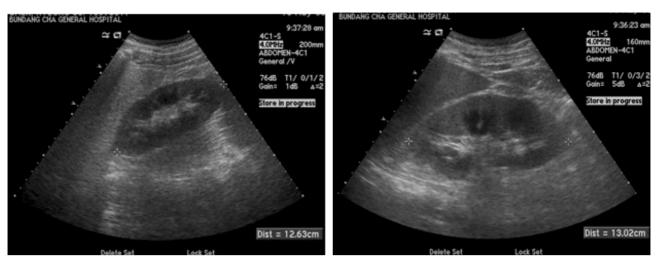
Abdominal ultrasonographic findings. Both kidneys were enlarged (the right kidney 12.6 cm and the left kidney 13.0 cm in length), and their echogenecity increased.
